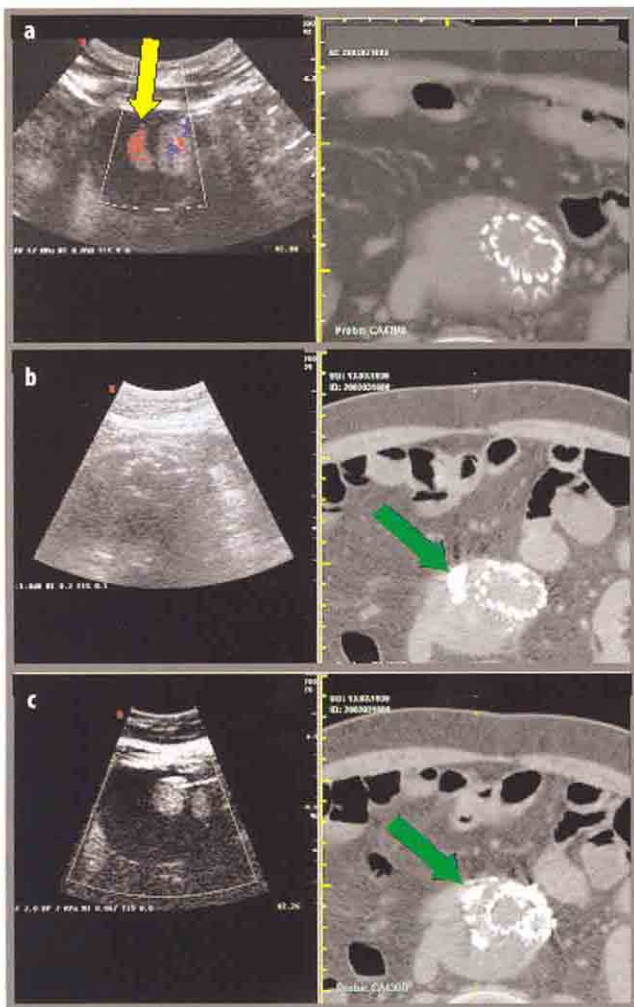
Follow-up evaluation after type II endoleak embolisation through CEUS-Low MI CD/CT fusion imaging. a Transversal Fusion CEUS/low MI CD scan combined with CT. b Analogous scan after embolisation. CT detects a hyperchoic material corresponding to embolisation materials in the leakage position (green arrow); the position corresponds to a. c Analogous follow-up scan. With CEUS, no sign of leak is detectable; prosthesis is regularly patent. The precision of the follow-up evaluation is guaranteed by the corresponding CT image
